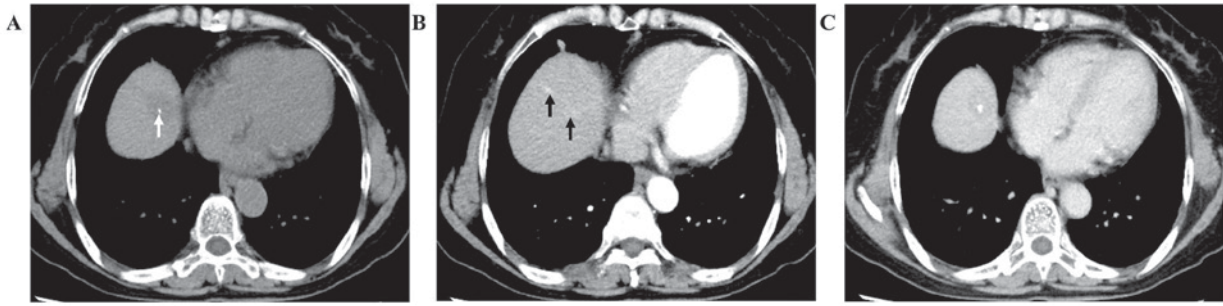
Computed tomography (CT) findings of the lesion. A round nodule with (A) punctate calcification (arrow), (B) mild to intermediate enhancement (arrows) and (C) persistent homogeneous enhancement of the nodule and the strip-like area on pre- and post-contrast CT.
